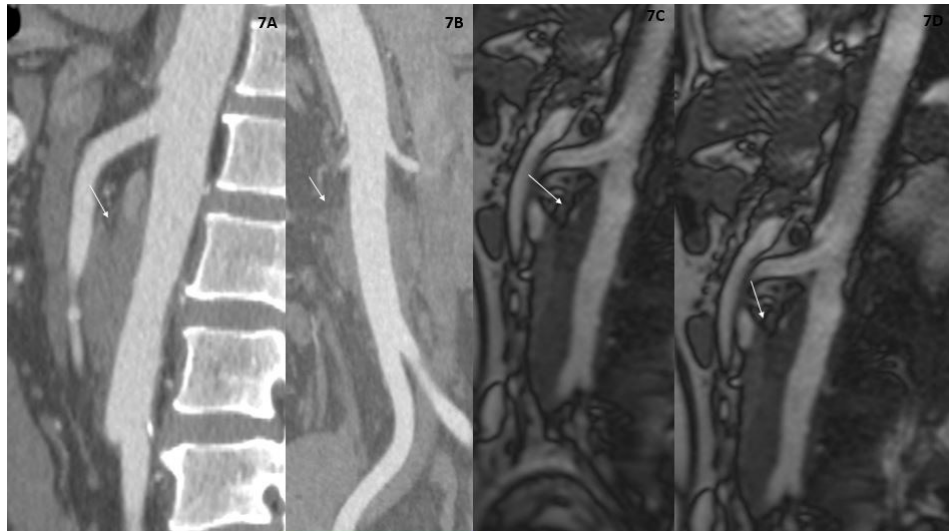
Case 2. Pre-steroid treatment images. A, B) Pretreatment sagittal and coronal oblique post-contrast CT image showing soft tissue thickening along infrarenal abdominal aorta indicated by white arrow. C, D) Pretreatment Sagittal T2W MRI image showing soft tissue thickening along infrarenal abdominal aorta indicated by white arrow
